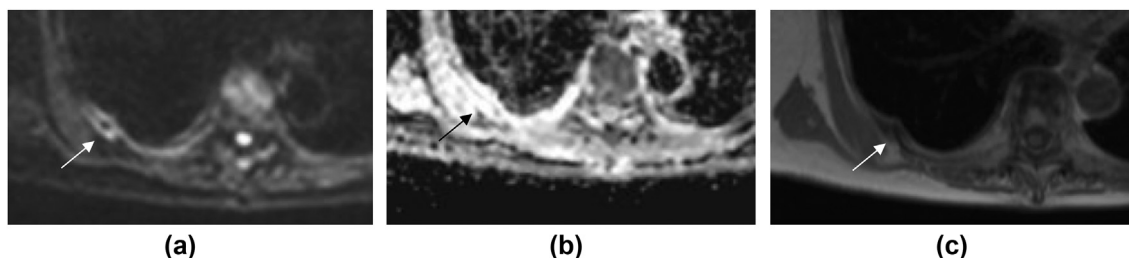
Rib fracture. (a) Axial $b = 900 \text{ s/mm}^2$ DW-MRI shows abnormal signal relating to a right sided rib (arrow) and (b) the ADC map shows high ADC indicating oedema (arrow). (c) The corresponding fat-only Dixon MRI image demonstrates an underlying well-margined likely benign fracture (arrow).
